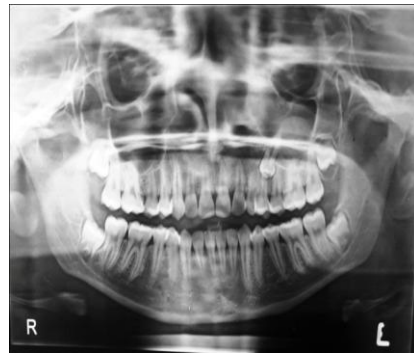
Digital Orthopantomograph
